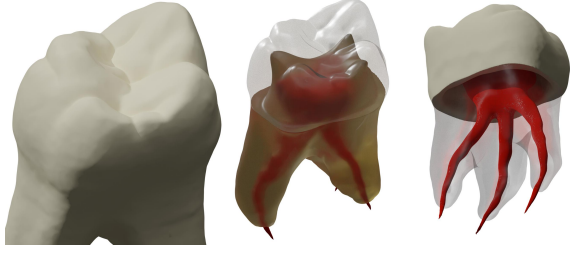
Anatomical tooth model. Our model of tooth #26, manually designed based on CT data. *Left*: The crown of the tooth, which consists of enamel. *Center*: The inner dentin layer. *Right*: The pulp chamber and roots.
